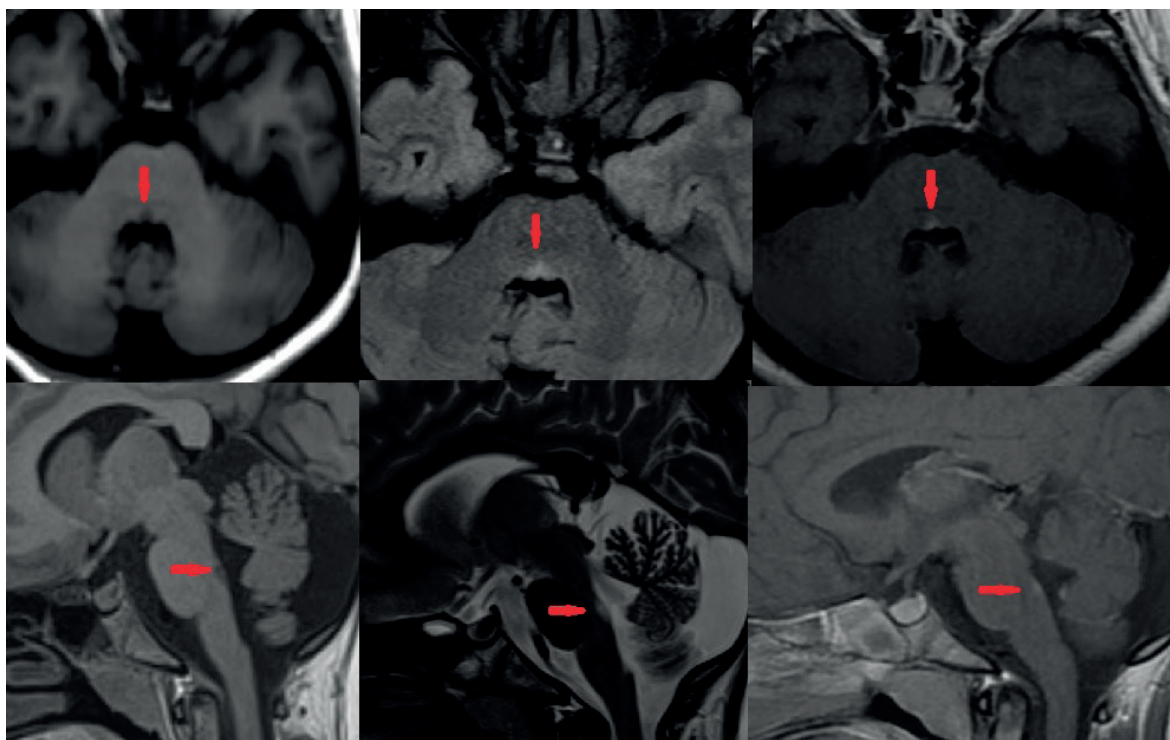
Cranial MRI: The signal increase in an area of approximately 3.5 mm was observed in the T2A and FLAIR images at the colliculus facialis level at the pons posterior level.
